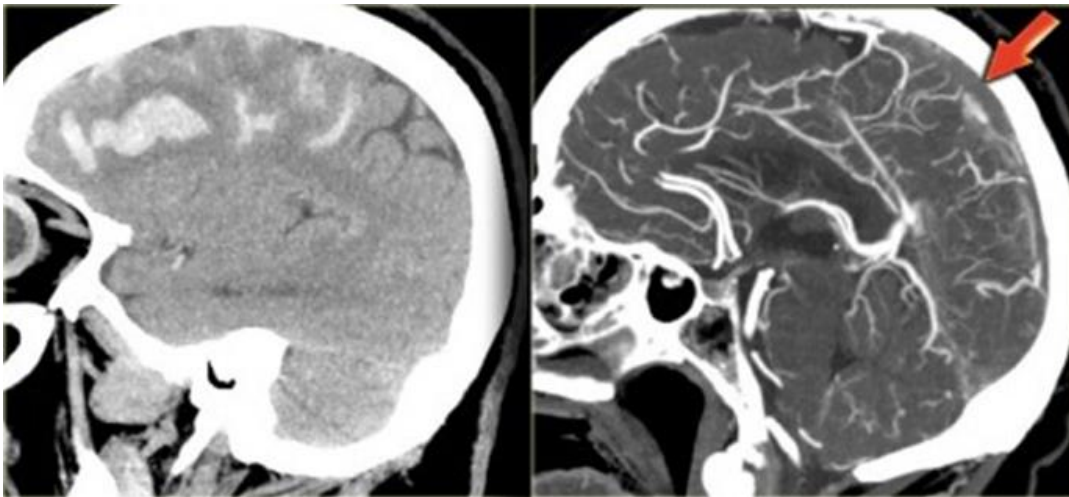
On the left reconstructed sagittal CT-images in a patient with bilateral parasagittal hemorrhage due to thrombosis of the superior sagittal sinus. The contrast enhanced image indicates the filling defect caused by the thrombus.
